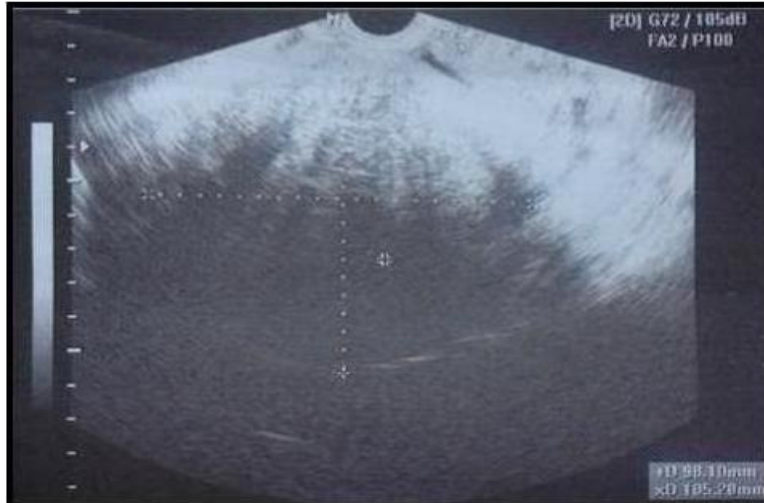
Vaginal ultrasound of twisted ovarian fibroma (our case).
